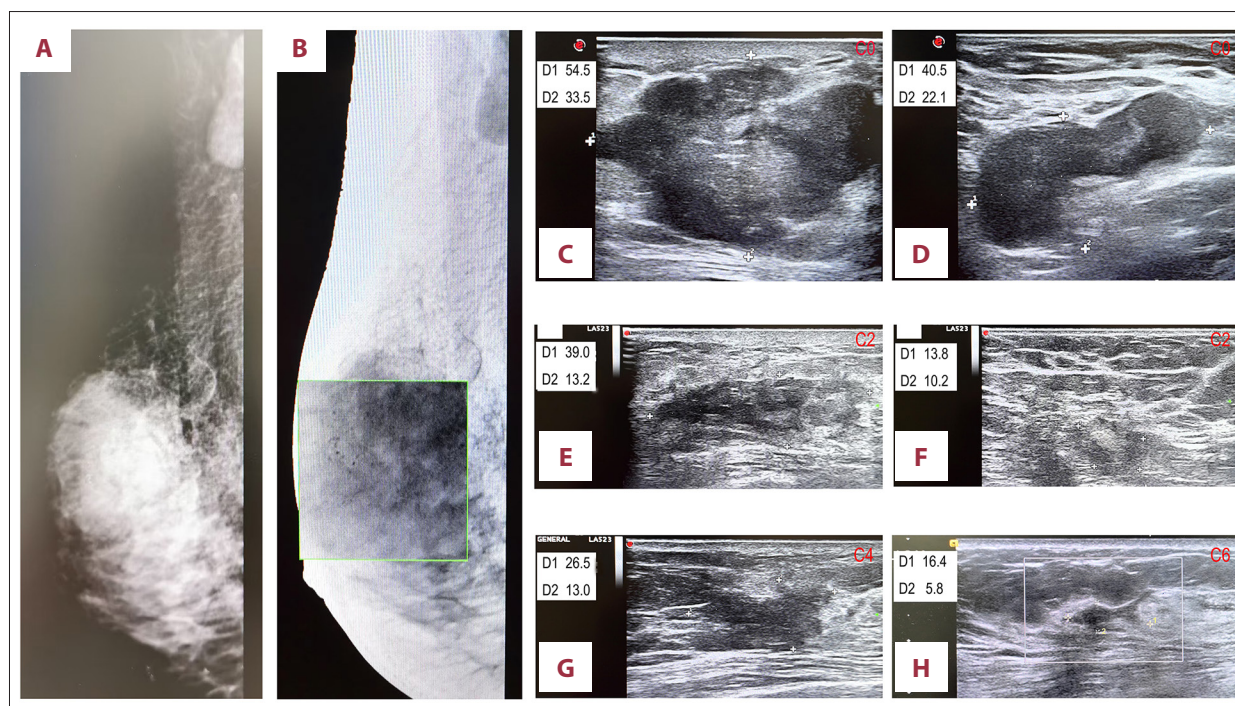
Tumor imaging at diagnosis and during neoadjuvant therapy. (A, B) Baseline mammography reveals a breast mass with internal calcifications and an enlarged axillary lymph node. The calcifications are better visualized on the inverted image (B). (C, D) Baseline ultrasound reveals the breast mass and (D) an enlarged axillary node. (E, F) Ultrasound after cycle 2 (C2) demonstrates the breast mass (e) and the axillary node (F). (G, H) Ultrasound after C4 (G) and C6 (H) demonstrates progressive tumor shrinkage. C, cycle; D1, longest diameter; D2, shortest diameter (mm).
